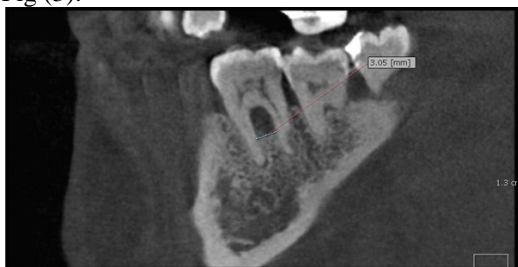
CBCT FW measurement
